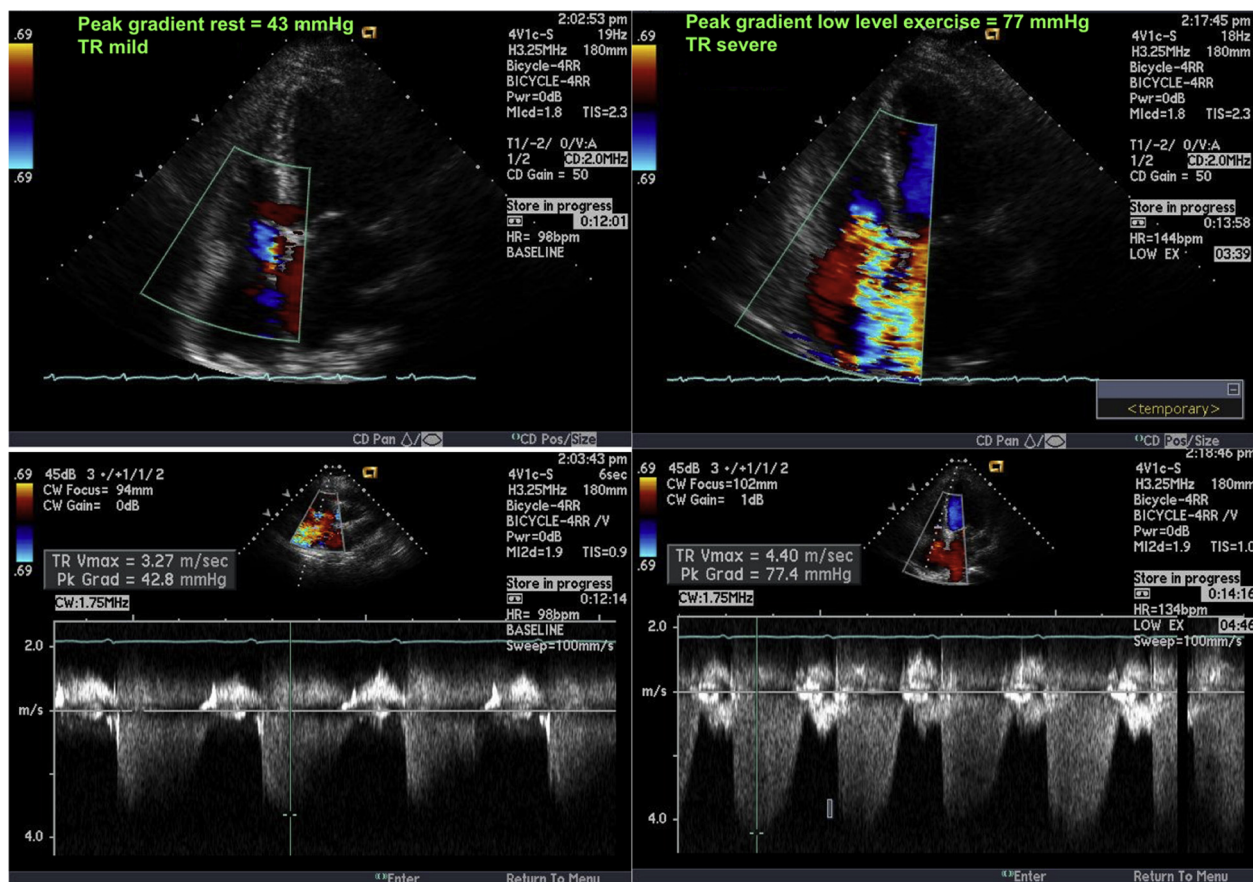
(Top left) Still frame from 2D real-time image of four-chamber apical view showing normal RV size and shape and mild tricuspid regurgitation (TR). (Top right) At peak exercise the right ventricle dilates, function qualitatively decreases, and moderate to severe TR appears by color flow. (Bottom left) Rest Doppler shows moderately elevated pulmonary pressure at 43 mm Hg (+RA). (Bottom right) At peak exercise, PAP is 77 mm Hg + RA, the TR jet is denser consistent with an increase in regurgitant volume, and there is a shape change such the configuration of the continuous-wave signal has a sharper peak (despite a sweep speed of 100 mm/sec), possibly indicating a TR v wave.
